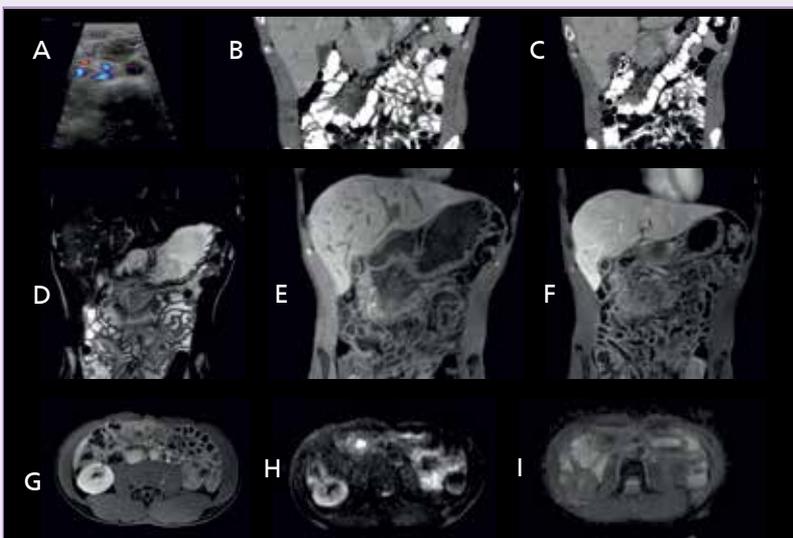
A. High resolution ultrasound image in the supraumbilical region shows an ill-defined hypoechoic lesion along the wall of a large bowel loop with internal vascularity. B. Coronal contrast enhanced CT image of the patient shows thickening of proximal transverse colon with an ill-defined enhancing omental lesion abutting transverse colon & stomach and ulcerations in the transverse colon (arrows in B) and adjacent extraluminal air foci (arrows in C). Coronal non-contrast BTFE image D shows ill-defined mass-like lesion in the transverse mesocolon with involvement of wall of transverse colon with hypointense signal on T1Wt image E. A peripherally enhancing area of flask-shaped micro-abscess is seen within (arrows in F & G) with diffusion restriction (H) and low ADC values in images (I)
